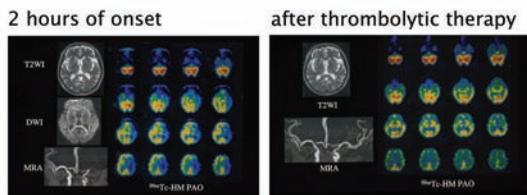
This patient showed sudden onset of right hemiparesis and consciousness disturbance. MRA indicated left middle artery occlusion without any signal change. MR T2WI and diffusion weighted images 2 hours of onset. ^{99m}Tc-HMPAO SPECT brain perfusion imaging showed 50% reduction of CBF. Acute thrombolytic therapy by recombinant tissue plasminogen activator resulted in immediate recanalization and recovery of CBF without ischemic brain injury.
